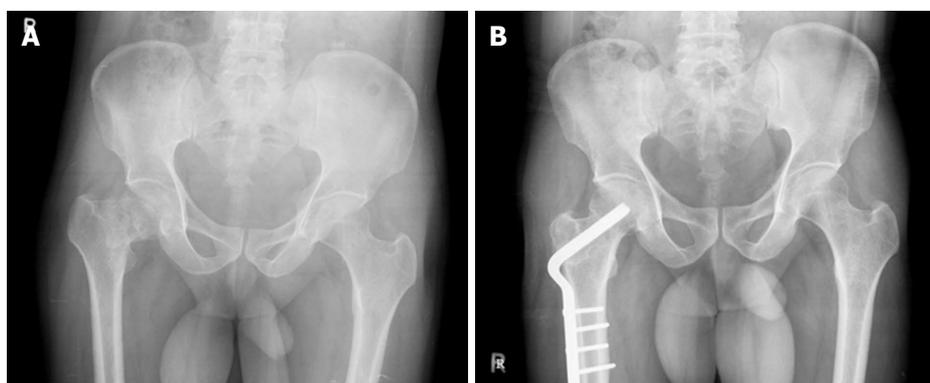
Ideal valgus correction. A: Anteroposterior radiograph of pelvis of a 45-year-old male with a 1-mo-old nonunion neck of femur fracture; B: At 5-year follow-up showing similar valgus orientation as the opposite hip, when the Harris hip score was 85.
